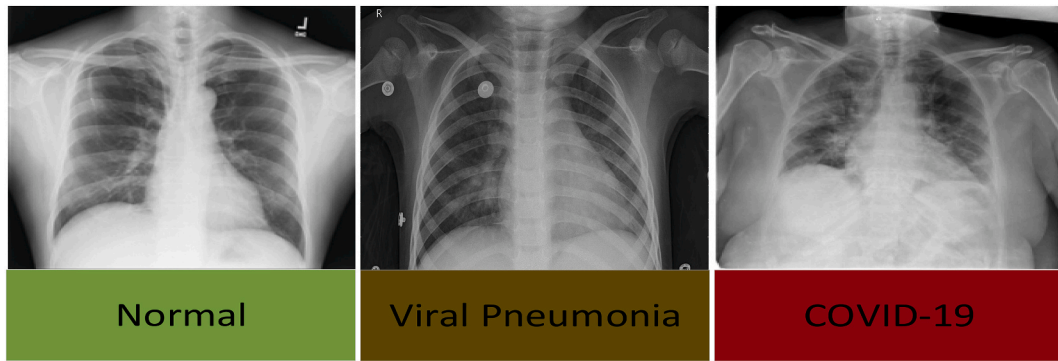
Example of chest X-ray images in the QaTa-COV19 dataset: (first column) Normal chest X-ray images, (second column) Viral Pneumonia chest X-ray images, (third column) COVID-19 chest X-ray images.
